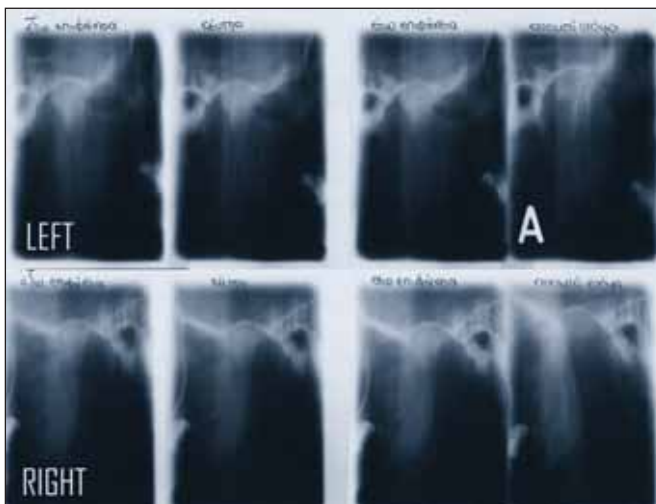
The tomographical views of the patient's TMJs (corrected by the use of submental-vertex radiograph).
